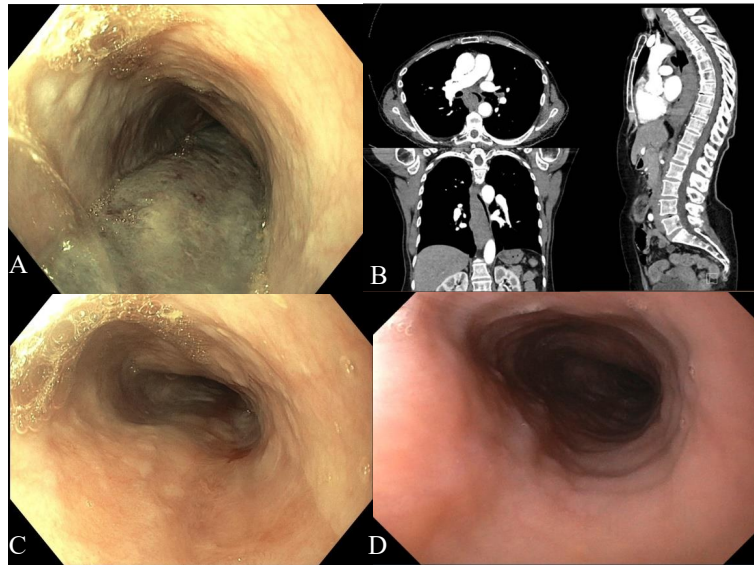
A) Esophagogastroduodenoscopy: long, submucosal hematoma extending along the right wall of the esophagus, with luminal narrowing and a small active bleeding point. B) Computed tomography (angiography): marked esophageal wall thickening from the oropharyngeal junction to the gastroesophageal junction C) One-month follow-up endoscopy showed complete resolution of the hematoma but revealed severe reflux esophagitis. D) Two-months follow-up endoscopy: complete mucosal healing.
